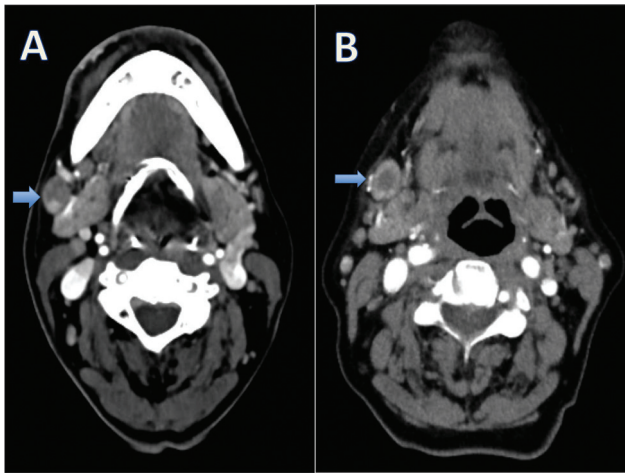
Contrast-enhanced computed tomography (axial sections) images from two different patients showing necrotic lymph nodes in right level 1b with thick nodular rim enhancement (A) and thick rim enhancement (B).
